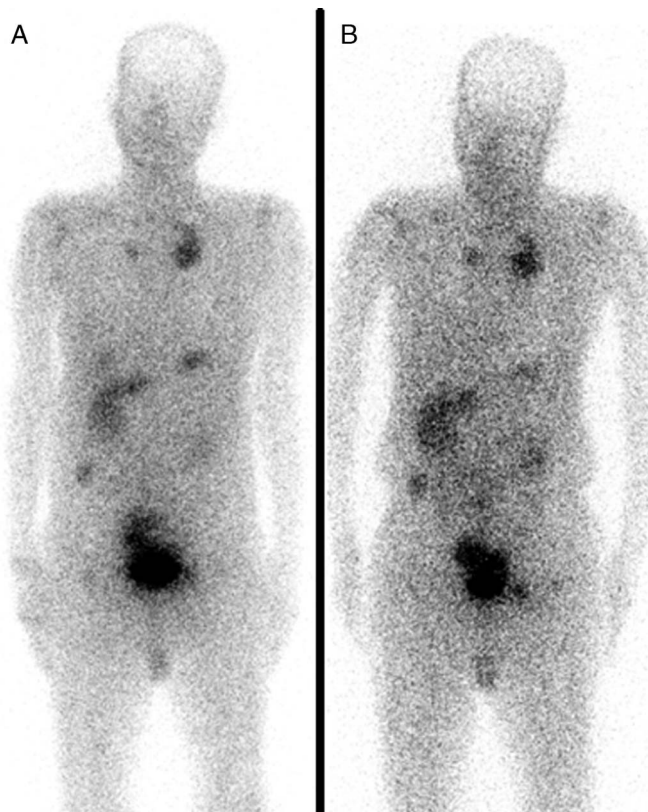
A 60-year-old man with metastatic colon cancer with a prior history of surgery and chemotherapy underwent scintigraphy with a diagnostic dose of ¹⁷⁷Lu-FAPI-46 that revealed multiple FAPI-avid lesions in the liver, lymph node, bone, and lung (A). The patient underwent 2 cycles of PRRT with ¹⁷⁷Lu-FAPI-46 (3.7 GBq per cycle) resulting in stable disease. The patient was still alive after follow-up 5.5 (B).
